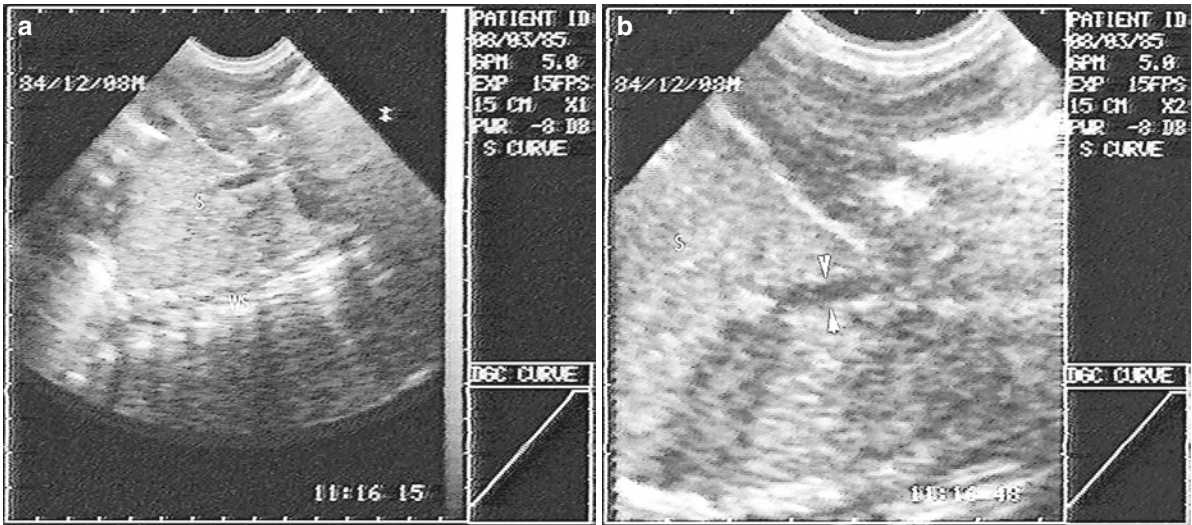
Three-month-old boy with breathing difficulty and left thoracic swelling. Chest X-ray showed a left inferior tumor shadow with displacement of the mediastinum to the right. (a, b) Sonography shows a consolidation with a liver-like echo pattern
